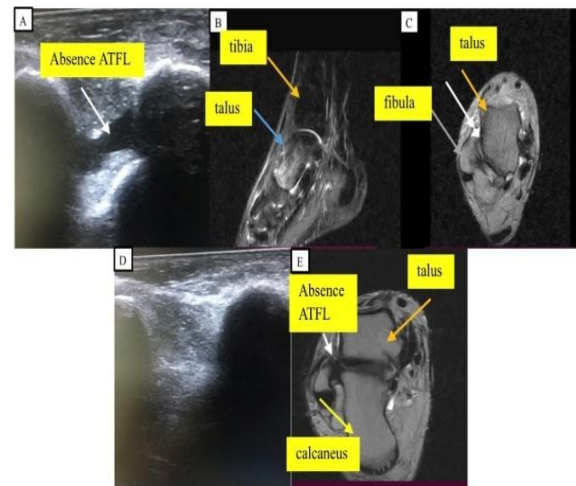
ATFL tear imaging. (A-C) A 25-year-old male presented 12 days after the initial ankle injury; (A) grayscale ultrasound shows absent ATFL with fluid collection at its site. (B) MRI sagittal STIR image shows bone marrow edema involving the talar head (C) Axial T2WI show absent ATFL with small fluid collection. (D and E) A 40-year-old women presented 10 hours after ankle trauma; (D) Ultrasound image shows no obvious ATFL tear (False negative). (E) Axial T2 MRI image shows absent ATFL.
